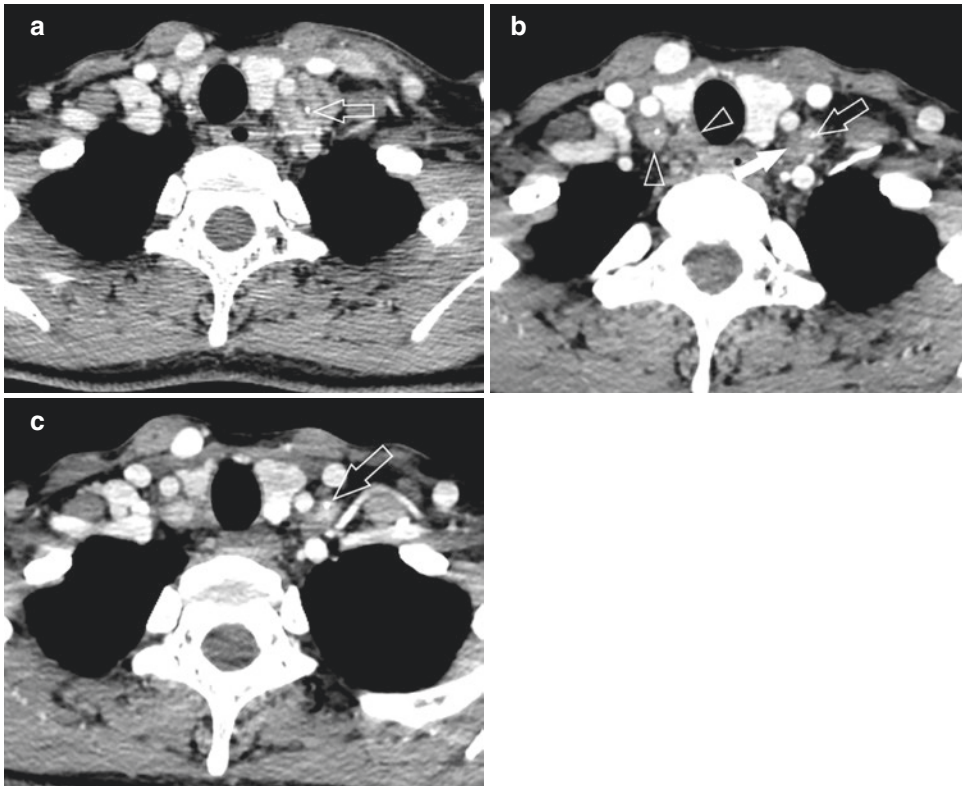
Calcified lymph nodes in tuberculous lymphadenitis on pre- and post-treatment CT. (a) Axial contrast-enhanced CT image before treatment shows inhomogeneously enhancing lymphadenopathy in the left lower internal jugular chain with a small round internal calcification (open arrow). (b) Axial contrast-enhanced CT image taken after 6 months of anti-TB drug therapy shows decreased size of the lymph node with low-density
